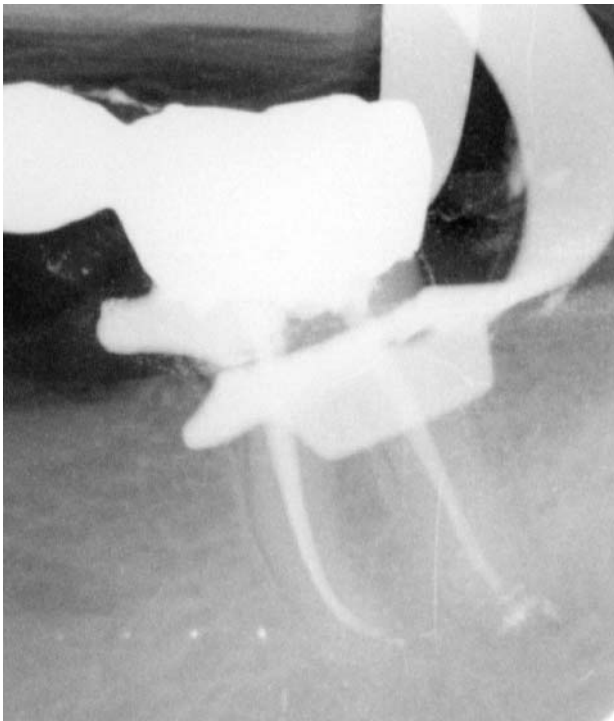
Immediate postoperative control X-ray of the performed obturation.
